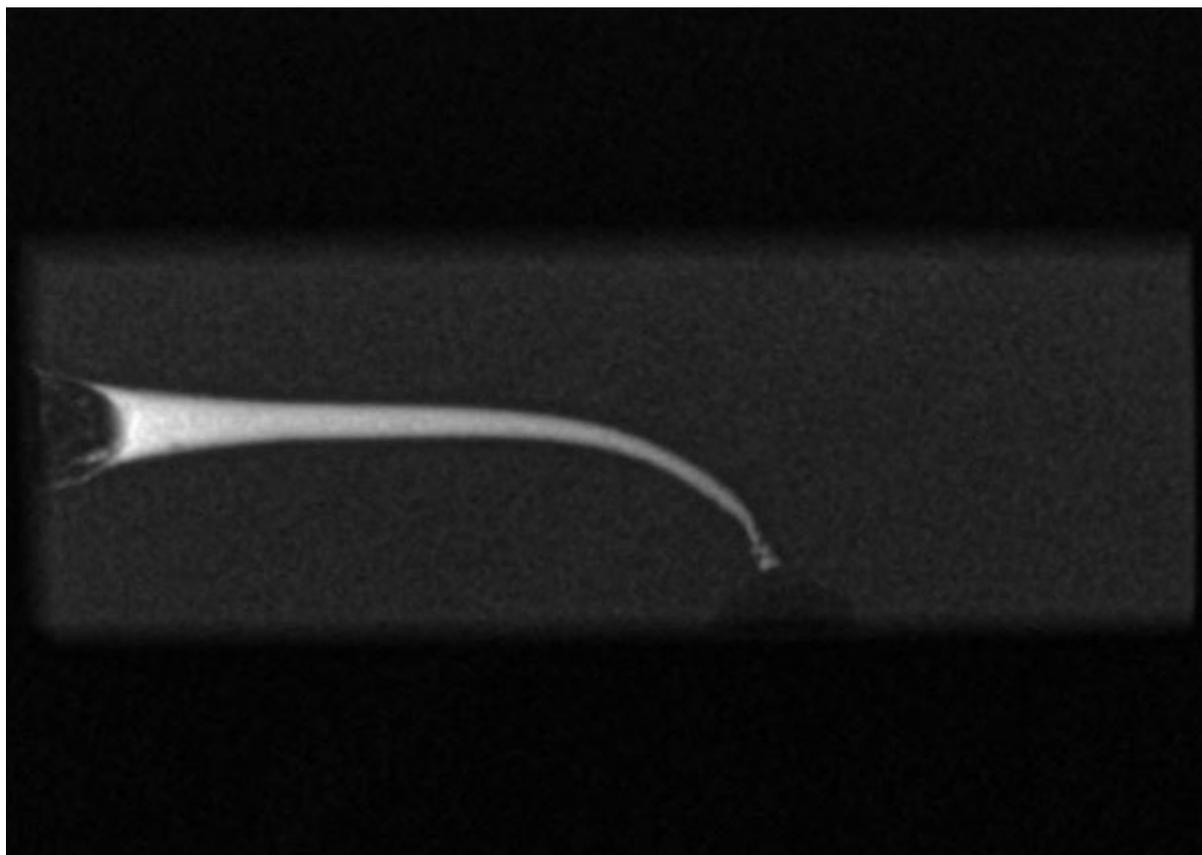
Radiograph in buccolingual direction.
